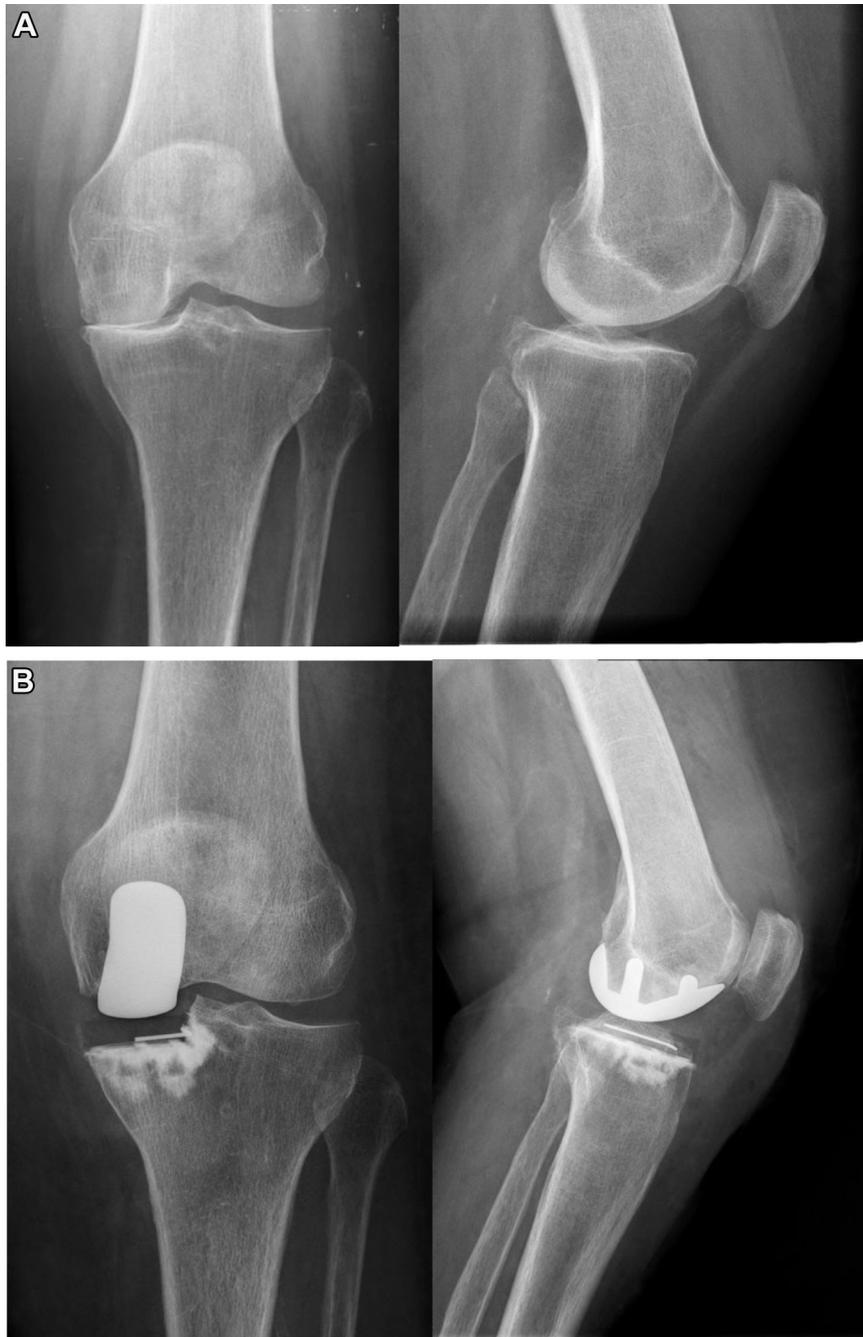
Radiographs of a female patient with a ZUK implant and an all-poly tibial component. (A) Preoperative X-rays of a 72-year-old female patient with severe pain on the medial side of her left knee. Her BMI was of 31.4 kg/m² before surgery. The patient reported a medical history of diabetes (NIDDM) and hypertension. The standing X-ray showed a medial grade 4 osteoarthritis; the patient's limb alignment was slightly varus. (B) X-rays at 6 years after surgery. The patient did not report any complaints about her knee. She can climb the stairs without any pain. The standing X-ray has shown a well-fixed implant without any progression of the lateral or patellofemoral arthritis. NIDDM, non-insulin-dependent diabetes mellitus.
